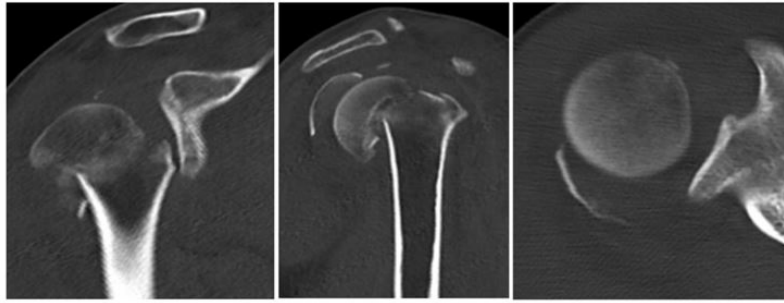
Coronal, Sagittal, and CT views of patient 1's right shoulder demonstrating comminuted 4-part fracture of the proximal humerus.
